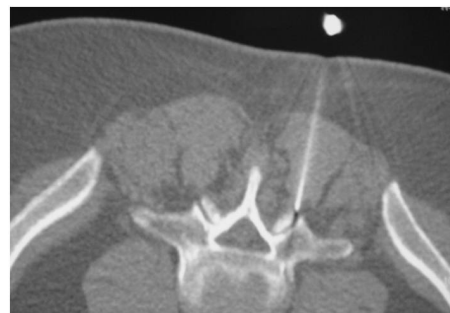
Axial CT scan with the needle inside the facet joint (patient in prone position, posterior access).
